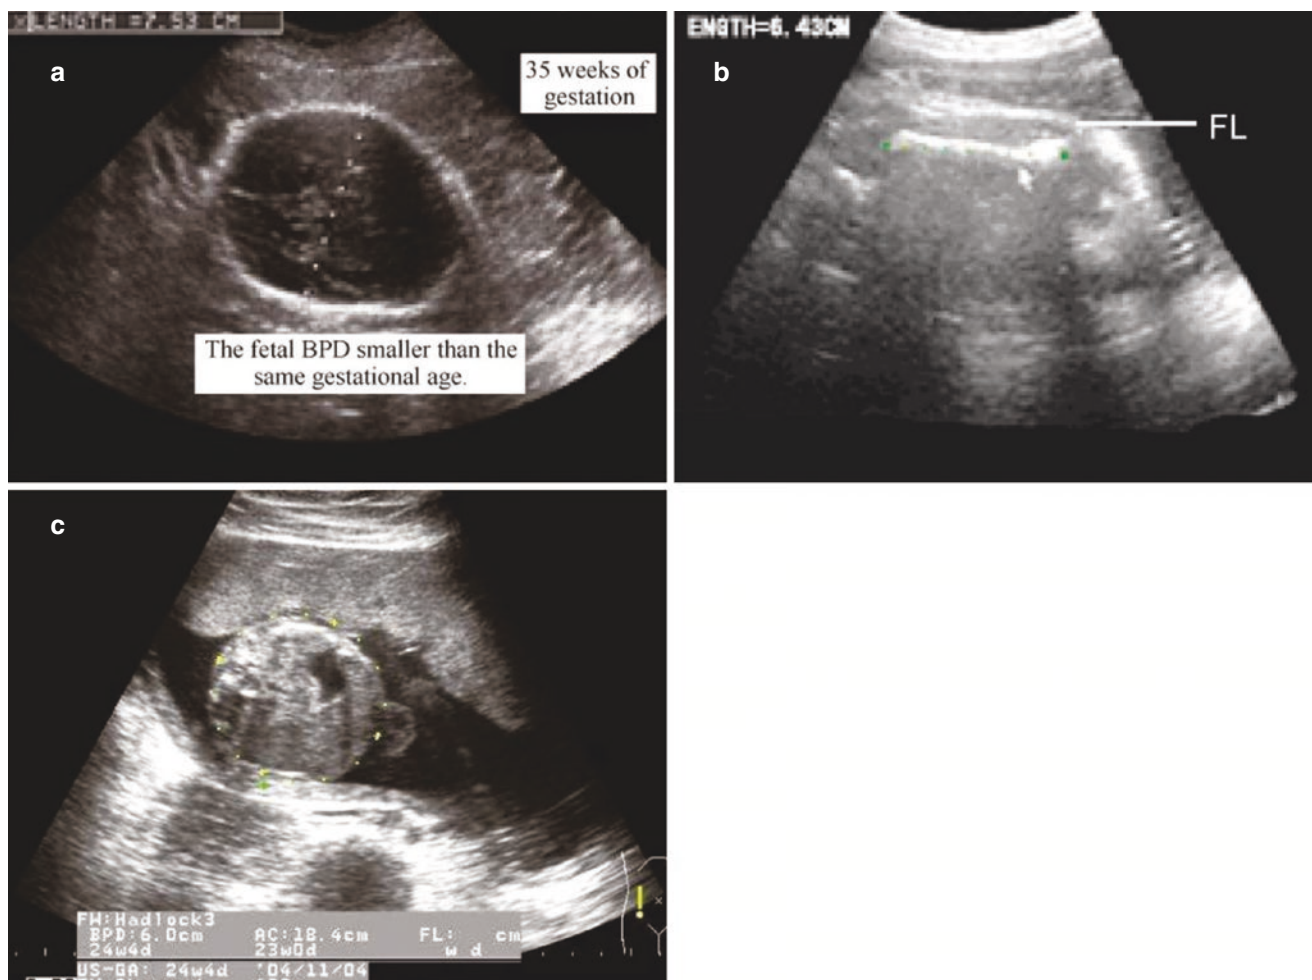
Ultrasonic diagnosis of IUGR. (a–c). At 35 weeks of gestation, the fetal BPD, FL, and AC are significantly smaller than those of the same gestational age
